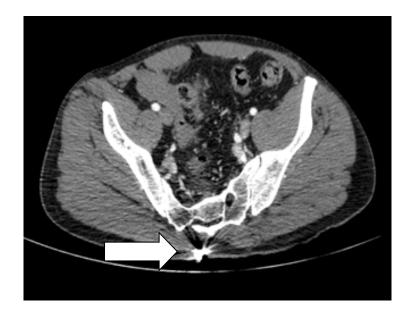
CT images of the patient with a gunshot injury (arrows)
